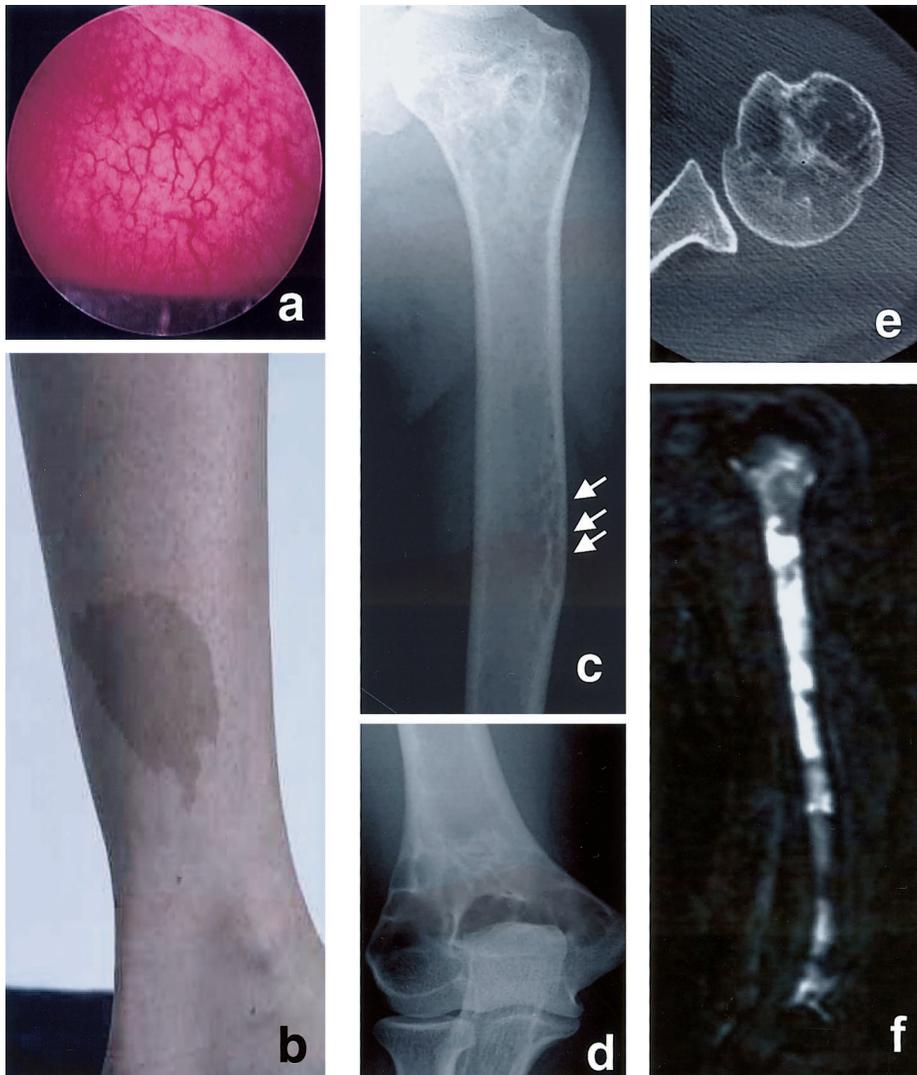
Clinical images. On hysteroscopy, the endometrium appears (a) highly vascular, suggestive of endometrial varicosities. (b) A café-au-lait spot on the distal lower extremity was significant for smooth borders (“coast of California”), inconsistent with those seen in association with FD and McCune-Albright syndrome. Radiographs reveal multiloculated lytic lesions with a honeycomb appearance in the (c) proximal metaphysis, midshaft (arrows), and (d) distal metaphysis of the left humerus. A CT image through the proximal humerus lesion (e) shows the multiloculated lesions occupying the medullary cavity. (f) A sagittal T2-weighted MR image of the left humerus shows hyperintense marrow replacement throughout.
